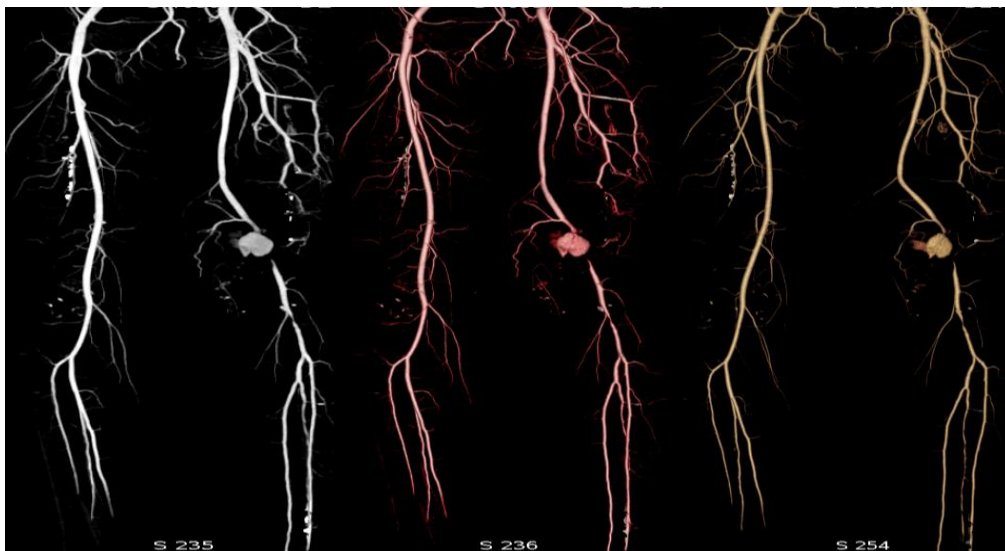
(A-C). CTA Maximum intensity projection (MIP) (A) and 3 D volume rendered (B,C) images show pseudoaneurysm of left popliteal artery.
